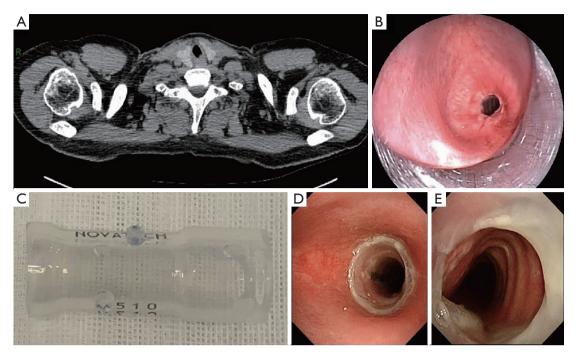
Severe subglottic stenosis treated with modified hourglass stent of case 1. (A) CT demonstrating severe stenosis of the subglottic airway. (B) Bronchoscopy showed circular scar stenosis, diameter of the narrow mouth approximately 6 mm. (C) Modified hourglass stent. Half year follow-up. (D) The upper end of the stent. (E) The lower end of the stent.
